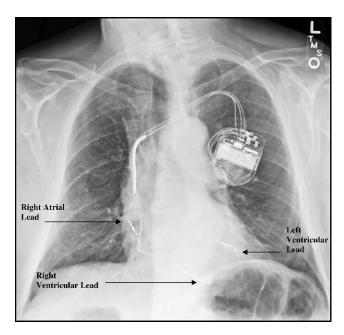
Chest x-ray showing pacing leads in the right atrium, right ventricle, and left ventricle.
